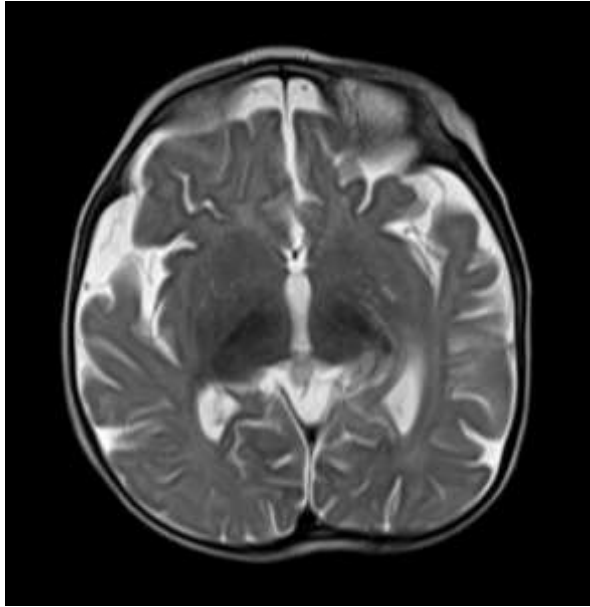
T2 sequence of brain MRI showing thinning of corpus callosum
